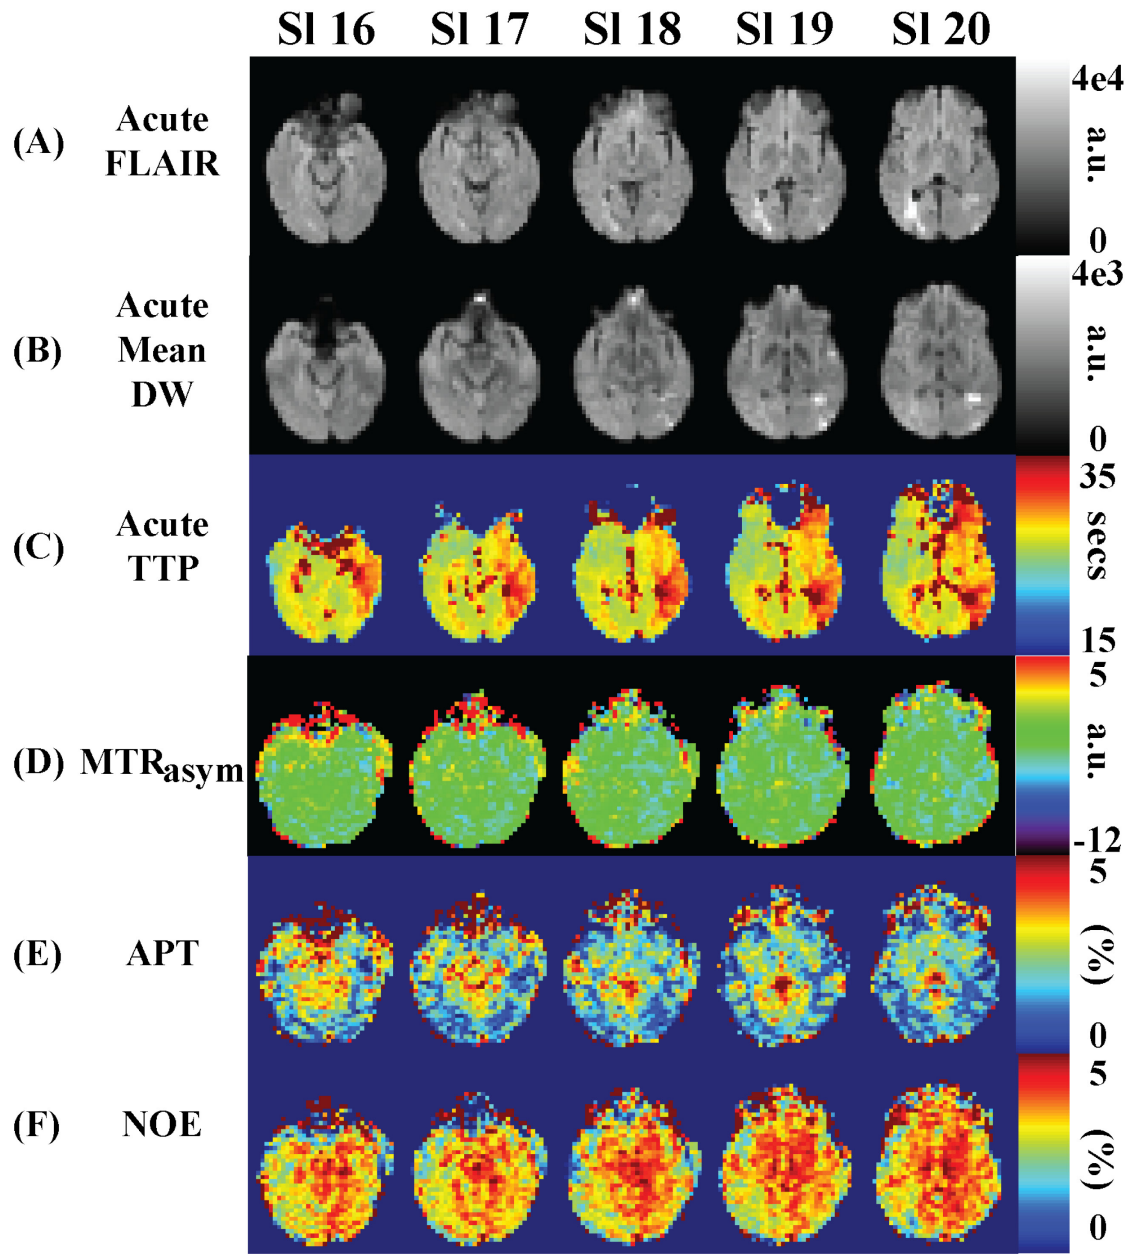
Processed data for carotid artery stenosis patient (Slices 16-20) (displayed in radiologic convention). (A) Acute FLAIR scan (B) Acute Mean Diffusion Weighted scan (C) Acute Time to Peak scan (D)  $MTR_{\text{asymmetry}}(3.5 \text{ ppm})$  (pH-weighted) (E) APT (F) NOE
